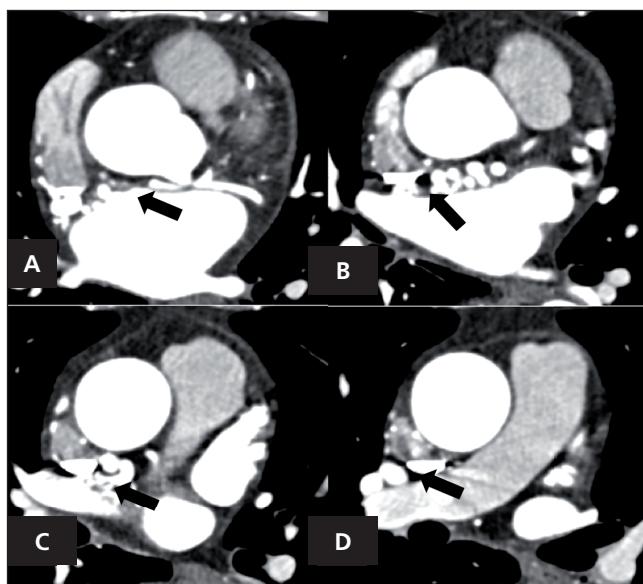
Sequential CTA (A–D) images showing a fistula (black arrow) extending from the LCx towards the RPA.
